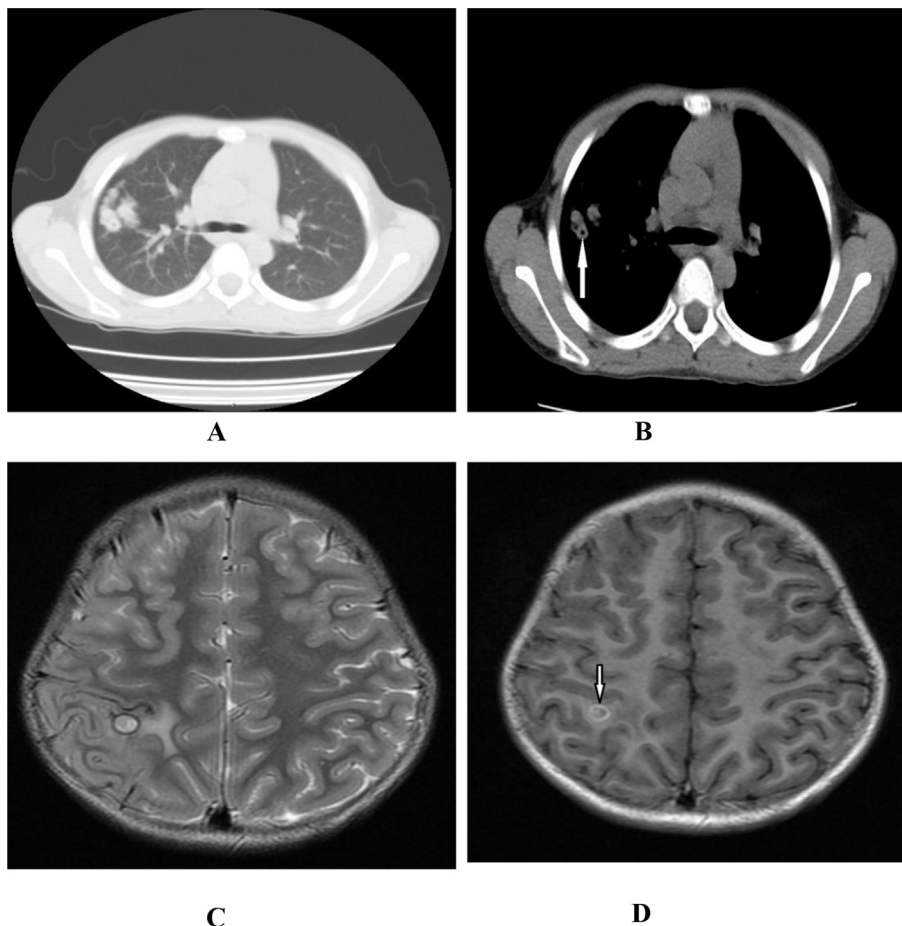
A 9-year-old boy with both pulmonary and cerebral paragonimiasis. Plain CT scan of chest shows a complex of multiple nodules (A) and worm cyst within the nodule (arrow) (B). Brain MRI shows a circular area (diameter 6 mm) of mixed signals with ring-shaped low T2 signal in the right parietal lobe; flow void, hemorrhage and surrounding edema can also be seen (C). Ring enhancement was seen after contrast administration (arrow) (D).
